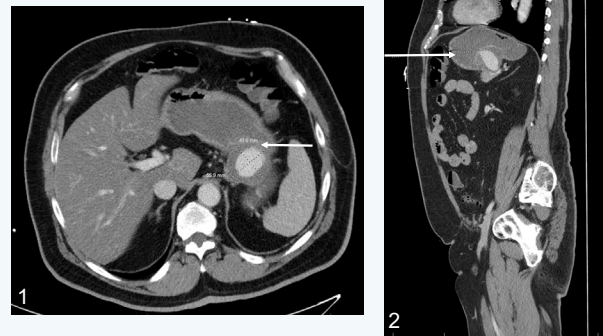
CT of abdomen obtained on day 2 of admission (axial and sagittal views). 5.7 cm x 5.6 cm pseudoaneurysm of the splenic artery with possible fistulization into the stomach
